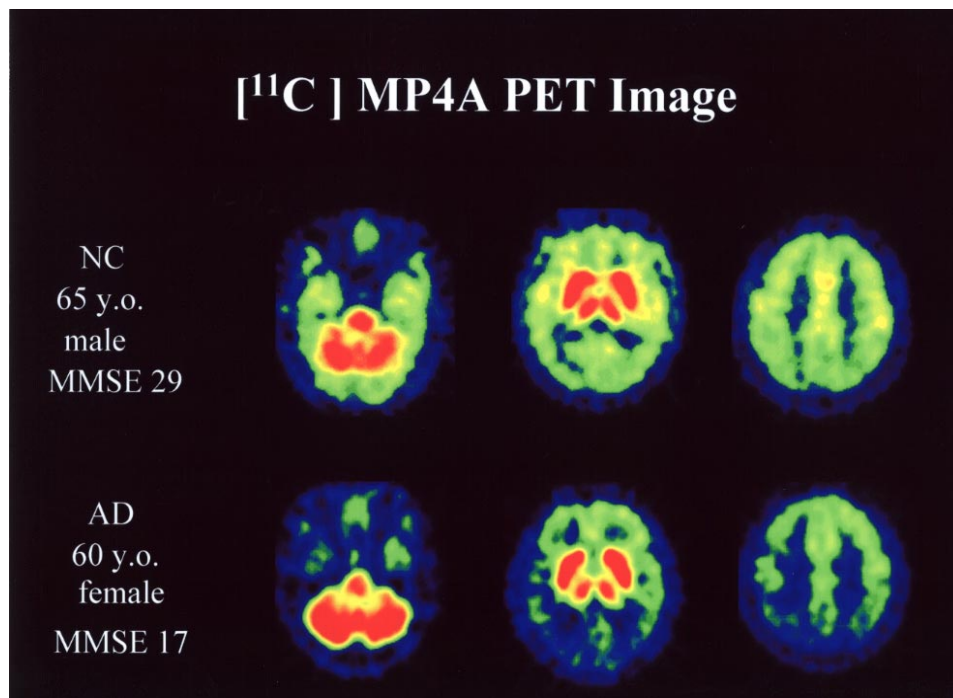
Typical [^{11}C]MP4A images in a patient with AD and a normal subject. PET brain images of the radioactivity distribution in brains obtained 20–40 min after injection of [^{11}C]MP4A image (late image) in a normal subject (*top*) and a patient with AD (*bottom*). The accumulation of radioactivity reflects not only regional AChE activity but also rCBF. The [^{11}C]MP4A image showed a more pronounced and extensive reduction than the [^{123}I]IMP SPECT image especially in the bilateral temporal and occipital cortices.
